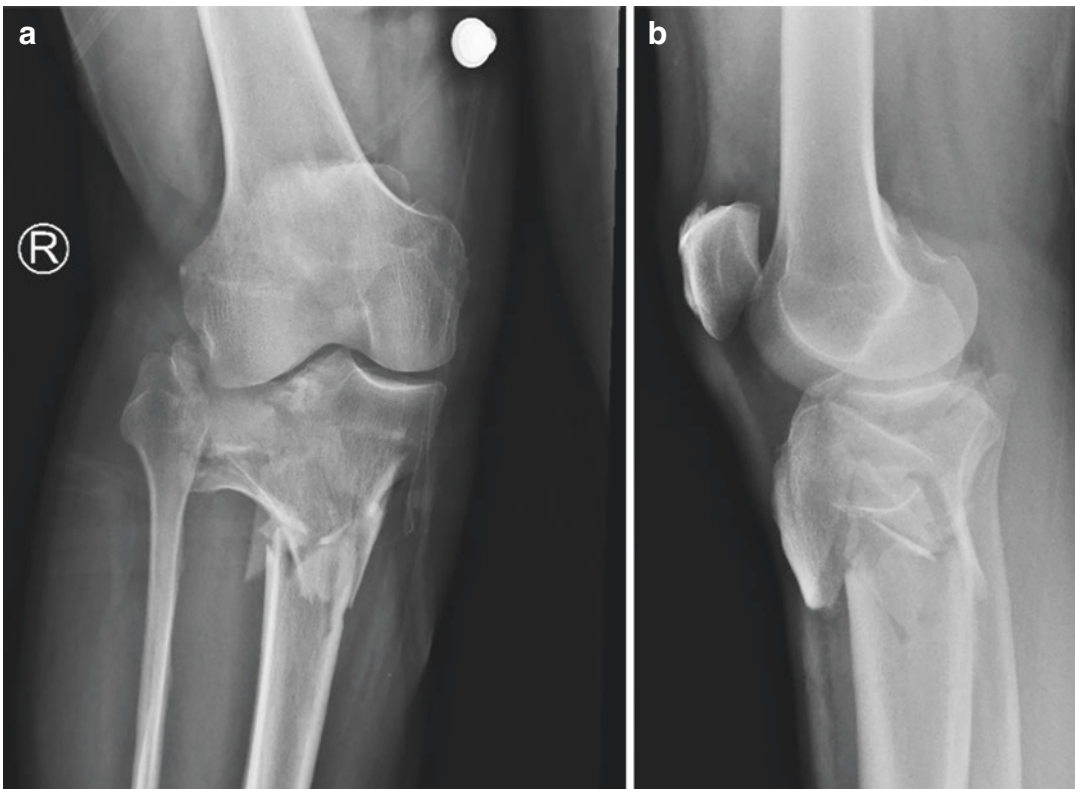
Anteroposterior (a) and lateral (b) radiographs demonstrating preoperative right knee injury consistent with a Type V Hohl and Moore proximal tibial fracture dislocation
